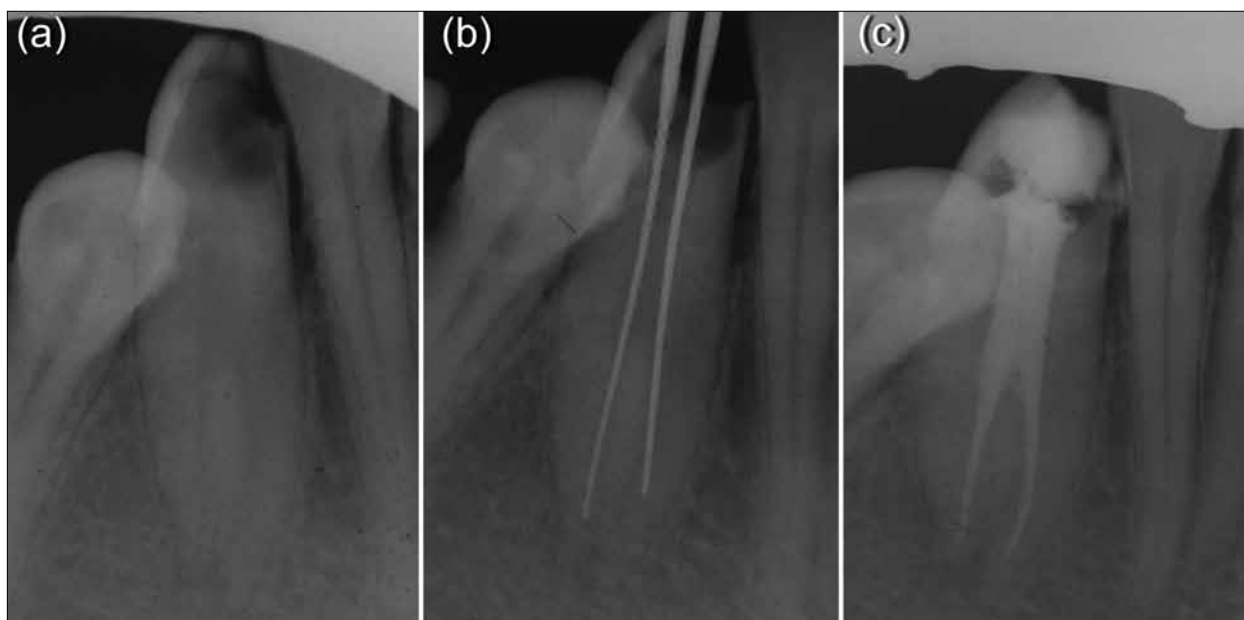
Case 1: (a) Preoperative radiograph of tooth 33 indicating two roots; (b) diagnostic length files placed into both root canals; (c) final obturation of the root canals using lateral compaction of gutta-percha.
